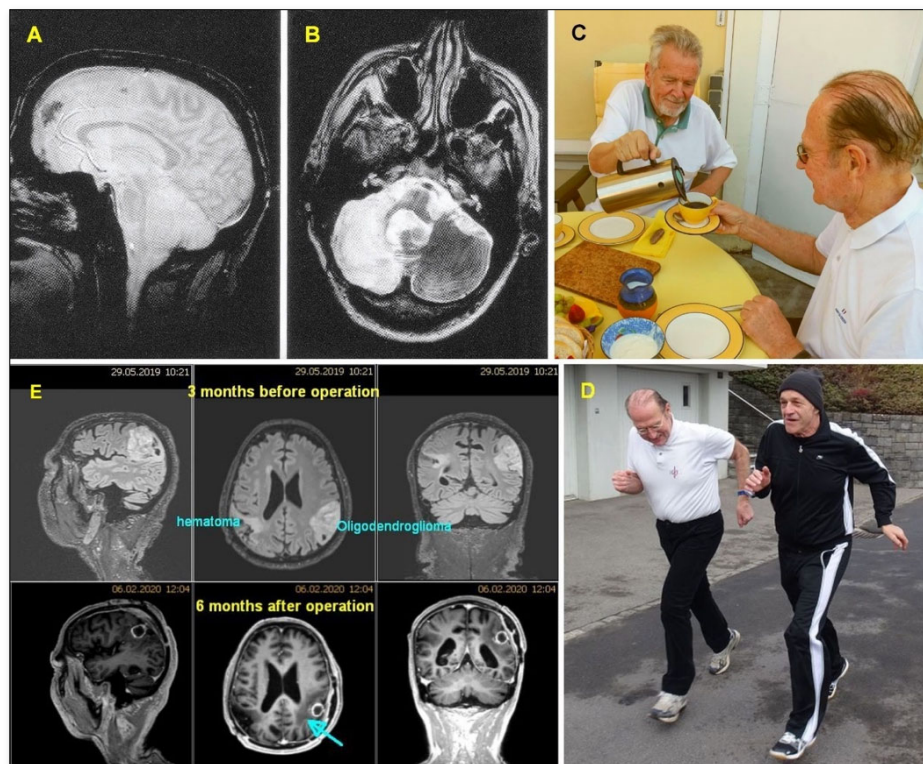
A, B. Dr. Cwienk suffered a frontal and temporal cerebrum injury with an open skull at the age of 55 and lost 80% of the cerebellum. He was given up by school medicine. Three years after the accident CDT was started. C. Through 21 years of Coordination Dynamics Therapy he is still having a meaningful life. In spite of coordination problems, he is able to give the Author coffee and have a high-level conversation with him. At the beginning of therapy, 20 hours therapy were administered to the very cooperative patient. Now with 80, he is training 9 h per week by himself to keep the level. If he would stop therapy for three days, his mental and physical performance would reduce dramatically, as the intelligent patient and his wife experienced before. D. The brain-cancer patient Hans during running again in interpersonal coordination with the Author through 4 months of CDT following the cancer removal (anaplastic oligodendroglioma WHO III). E. MRI's before and after the cancer operation. On the other side of the brain there is also damage from an old hematoma.
